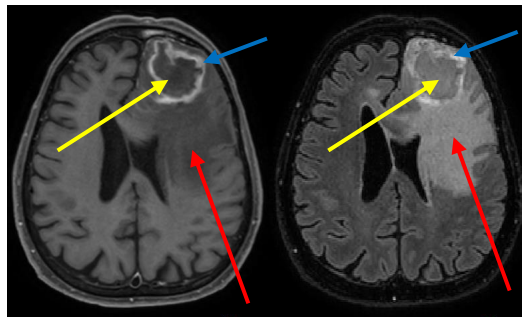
The brain image with brain edema, contrast enhanced and non-enhanced part of a brain tumor, visualized in the axial plane, marked with arrows (red arrows: brain edema, yellow arrows: not contrast enhanced part of a tumor (an inner part of bordered area), blue arrows: contrast enhanced part of a tumor (a border of the inner part)). On the left: in the T_1 image brain edema represents the signal hypointensity, thus it is visualized with a dark color. On the right: in the FLAIR image brain edema represents the signal hyperintensity, thus it is visualized with a light color. This kind of a brain tumor is more hyperintense on FLAIR image.
